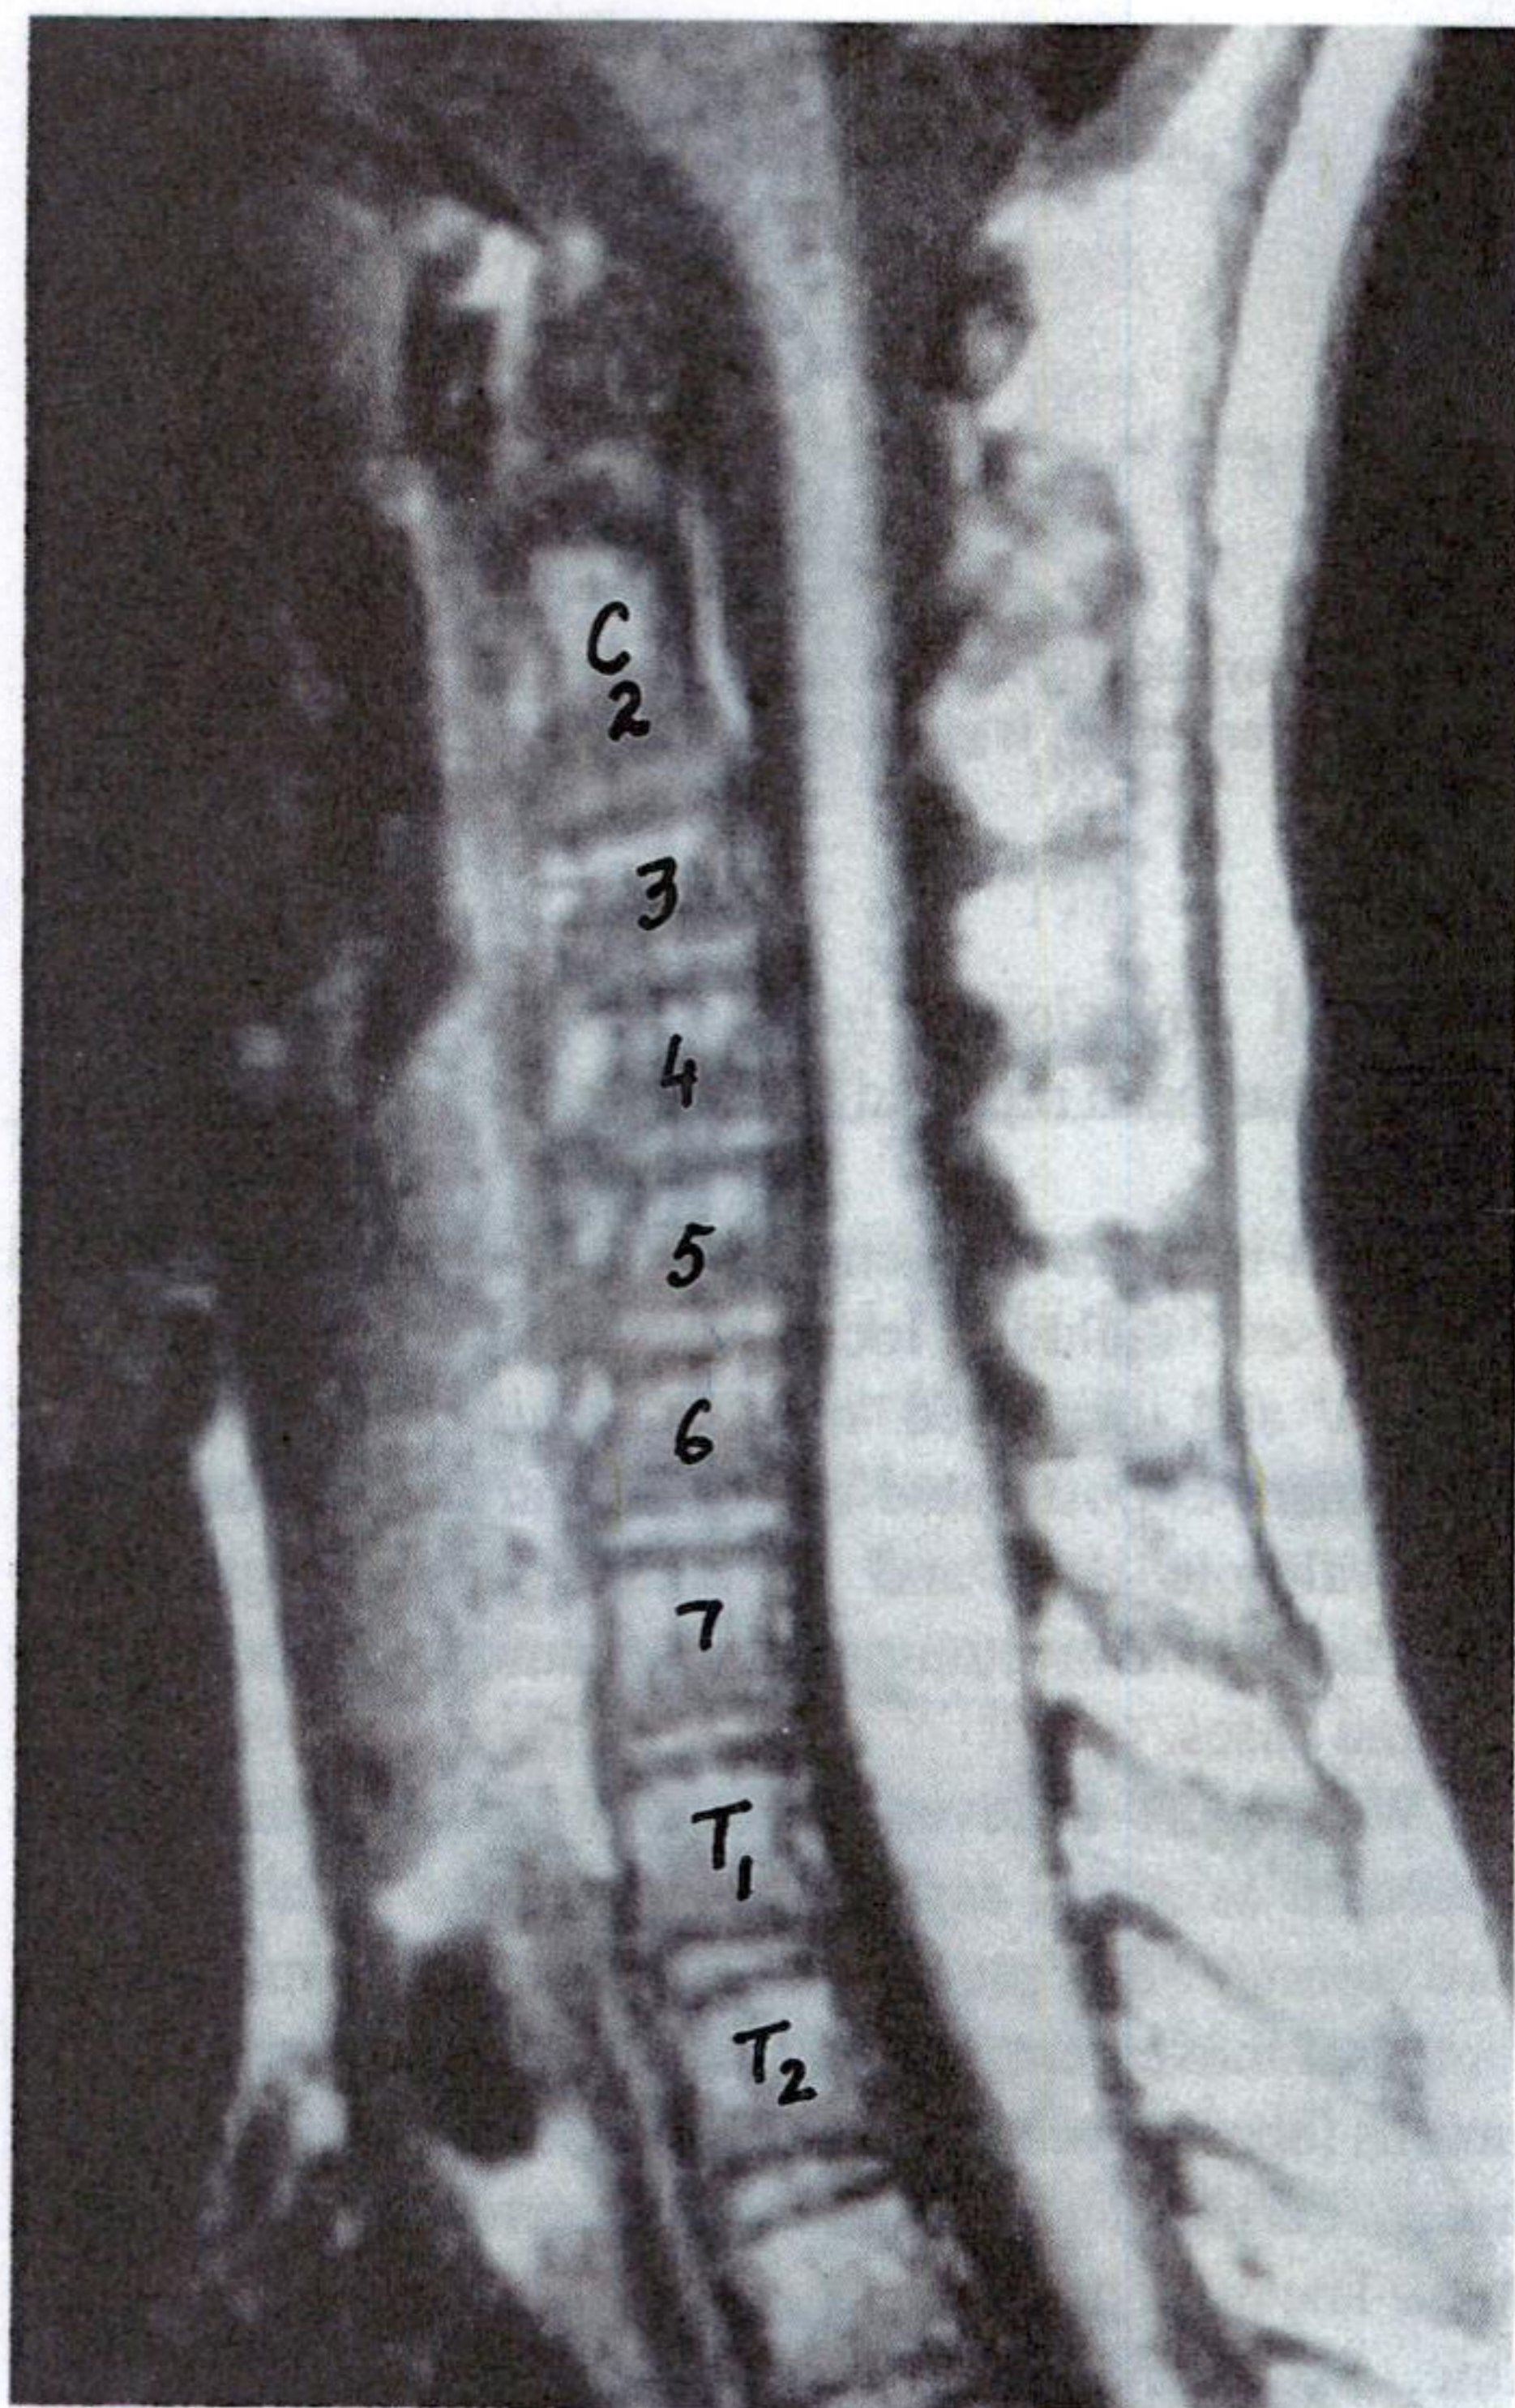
T1 MRI Scan showing spindle like enlargement of the cervical spinal cord from cervical; 5 to thoracic 1 segments with vertebral scalloping.
